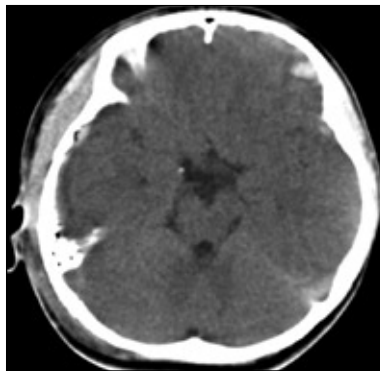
Computed tomography scan obtained 16 hours after injury reveals a marked decrease in the acute epidural hematoma and increase in the epicranial hematoma.
